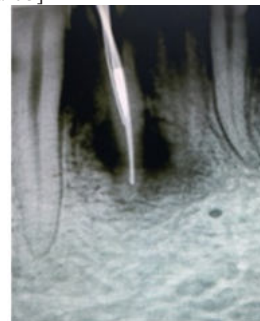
Radiograph showing 3 K-files braiding the sewing needle fragment in 41
